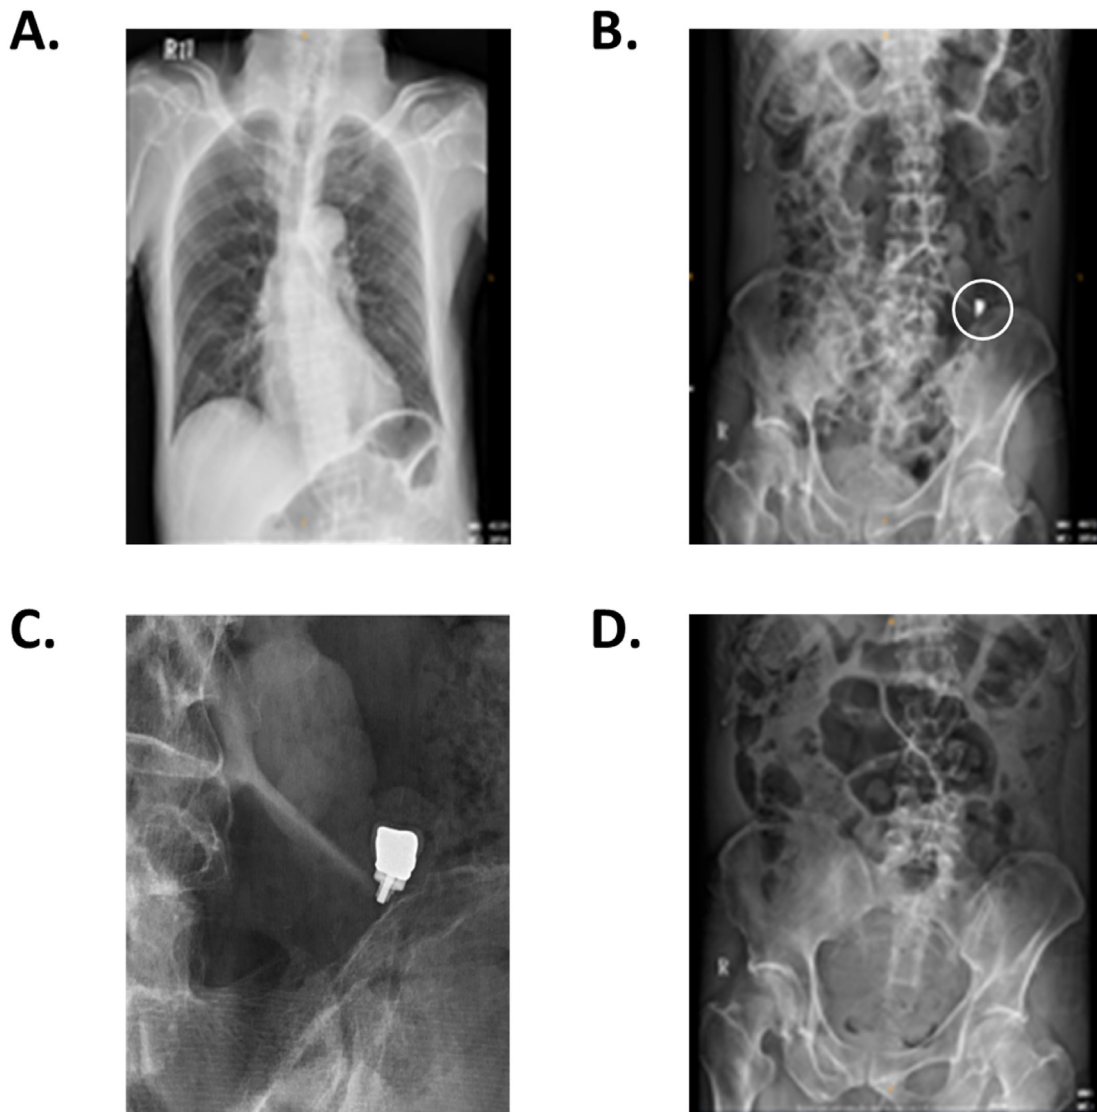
In Case 8, an implant-supported crown was ingested into the digestive system and discovered during the routine dental examination. A. The chest radiograph showed no abnormalities. B. The abdominal radiograph revealed a radiopaque object near the median site of the left iliac bone. C. A magnified view of the abdominal radiograph identified the object as an implant-supported crown with a screw. D. Two weeks later, a follow-up abdominal radiograph showed no evidence of the radiopaque object.
